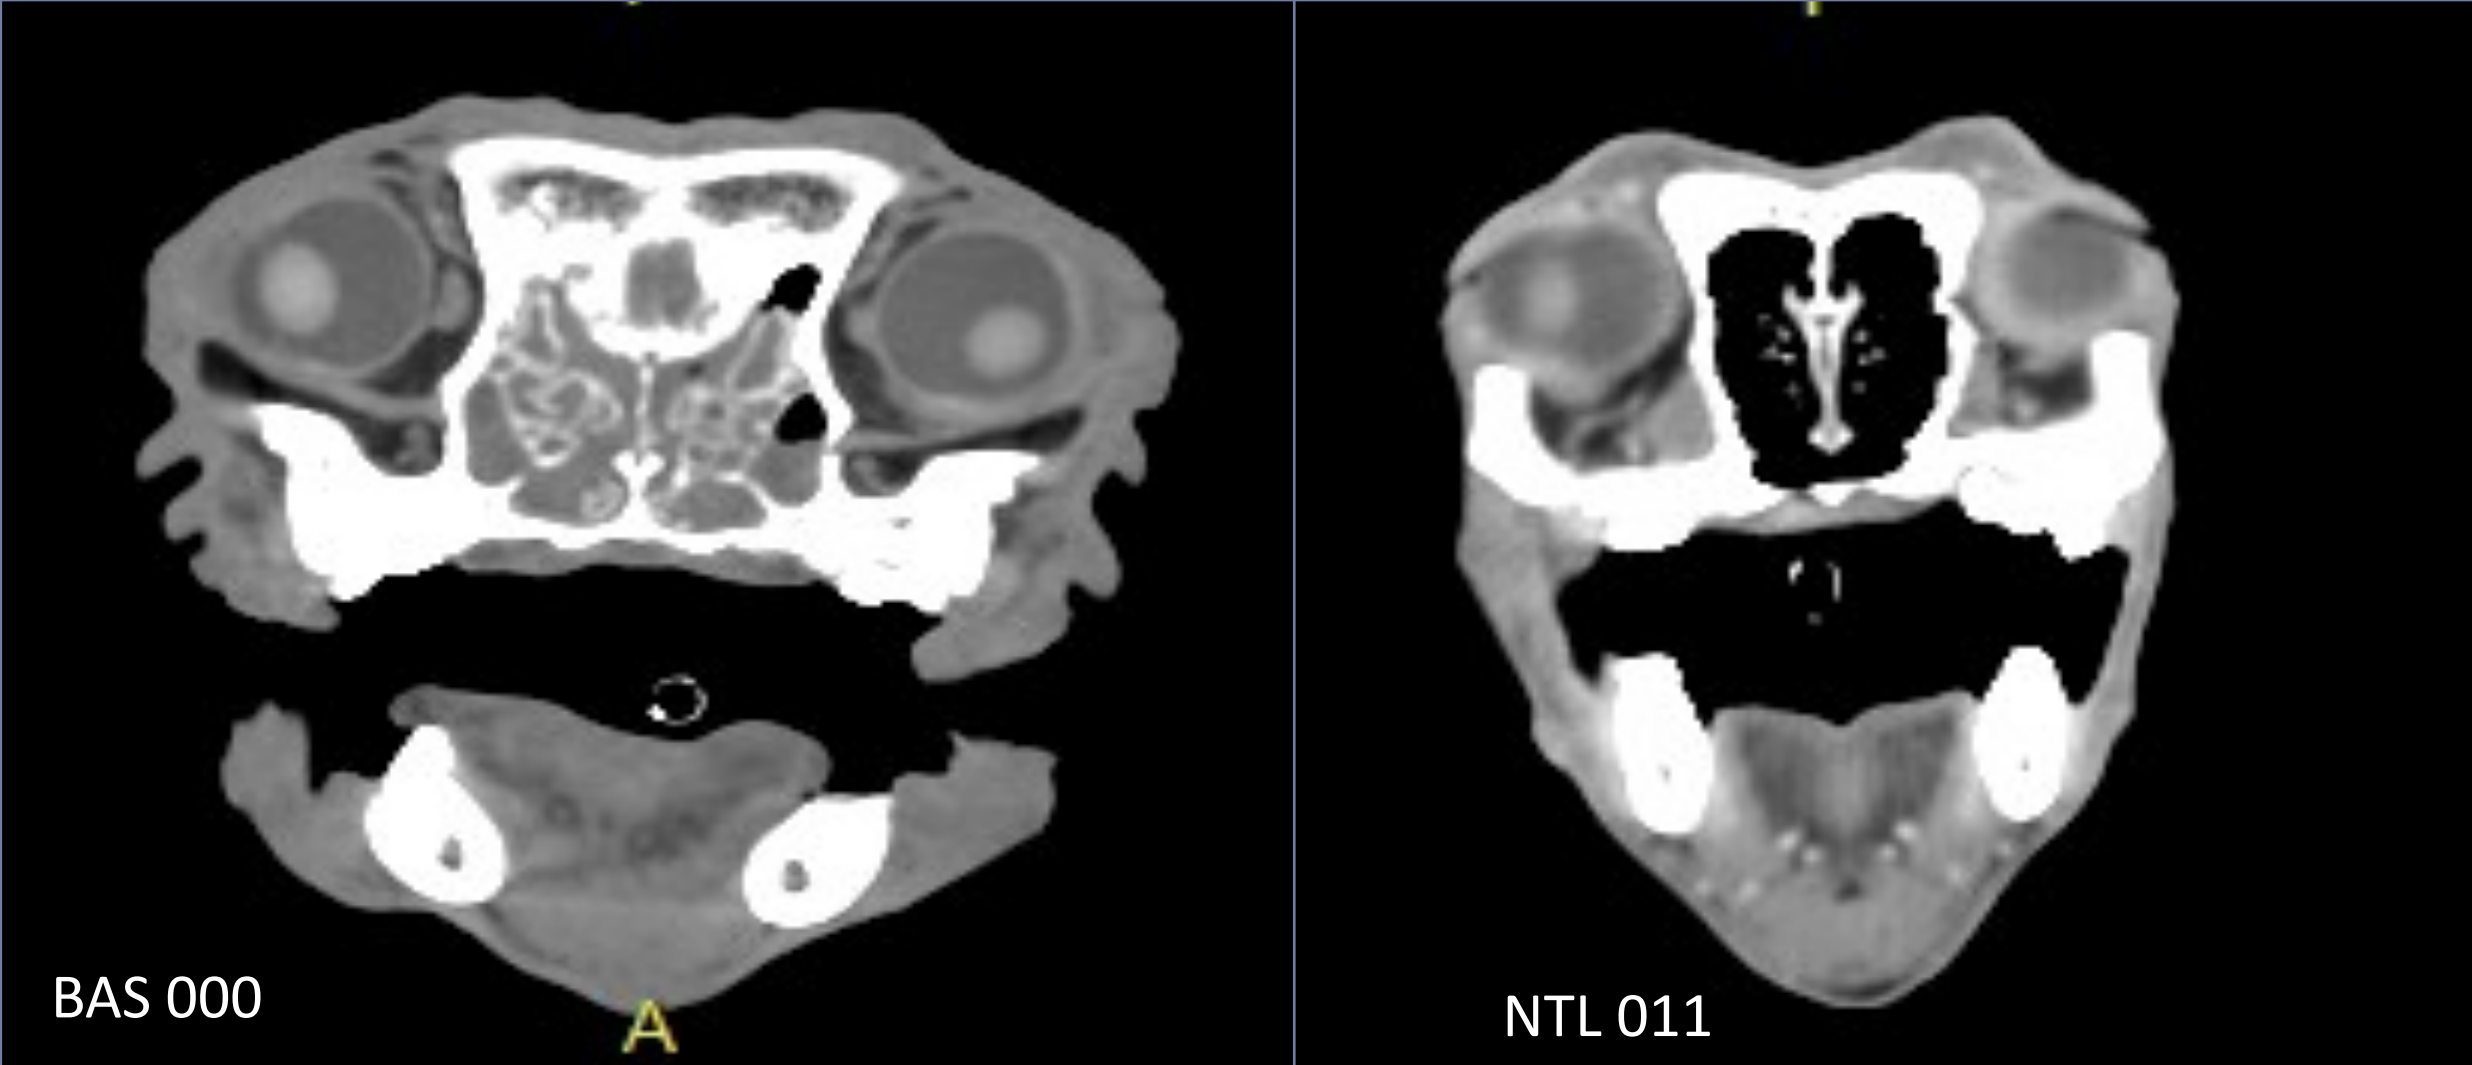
CT transverse images of nasal cavity. French bulldog (left), Norwich Terrier (right). The NT nares and intranasal components are similar to mesaticephalic breeds.
